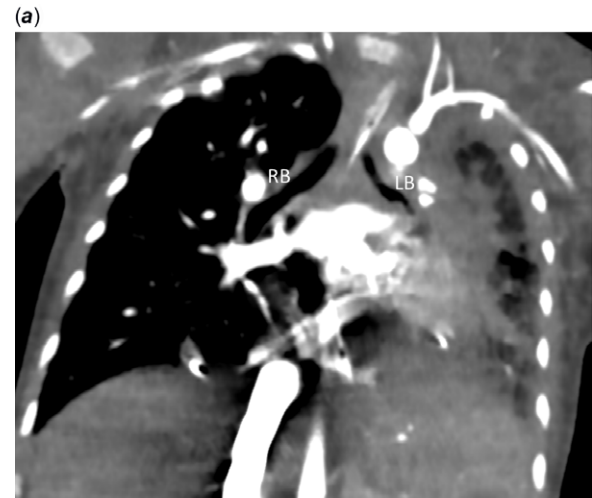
CT imaging showing intra-thoracic laterality defects. (a) Two-dimensional frontal CT angiogram with bilateral morphologically left bronchi (late first branching of both bronchi), RB = right bronchus, LB = left bronchus. (b) Three-dimensional CT imaging showing similar external shape of the two atrial appendages; RAA = right atrial appendage; LAA = left atrial appendage; Ao = aorta; PA = pulmonary artery; RV = right ventricle; LV = left ventricle.
